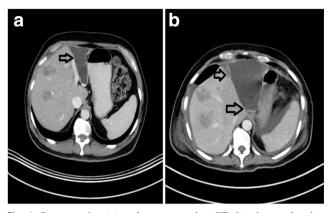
Pre-operative (a) and post-operative CT (b) picture showing hypertrophy of the left lobe of the liver next to the line of transection (short arrow)
